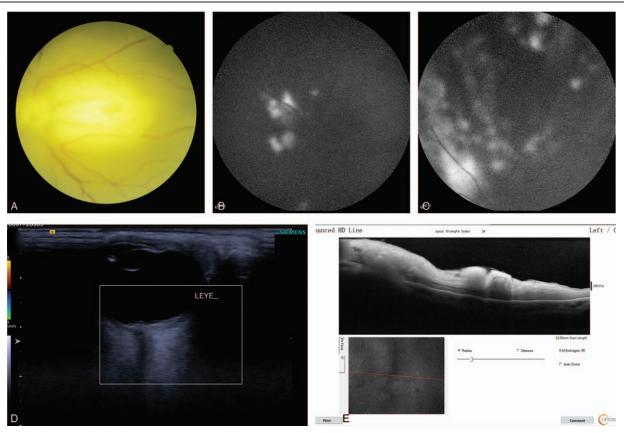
(A) Funduscopic examination of the left eye showed a pale and swollen retina with no cherry-red spot. (B and C) Fundus fluorescein angiography (FFA) revealed no retinal or choroidal perfusion. (D) Doppler flow imaging showed absent flow in the central retinal artery and vein. (E) In spectral-domain optical coherence tomography (SD-OCT), the retinal neurosensory layer exhibited edema and thickening with a corresponding increase in reflectivity.
